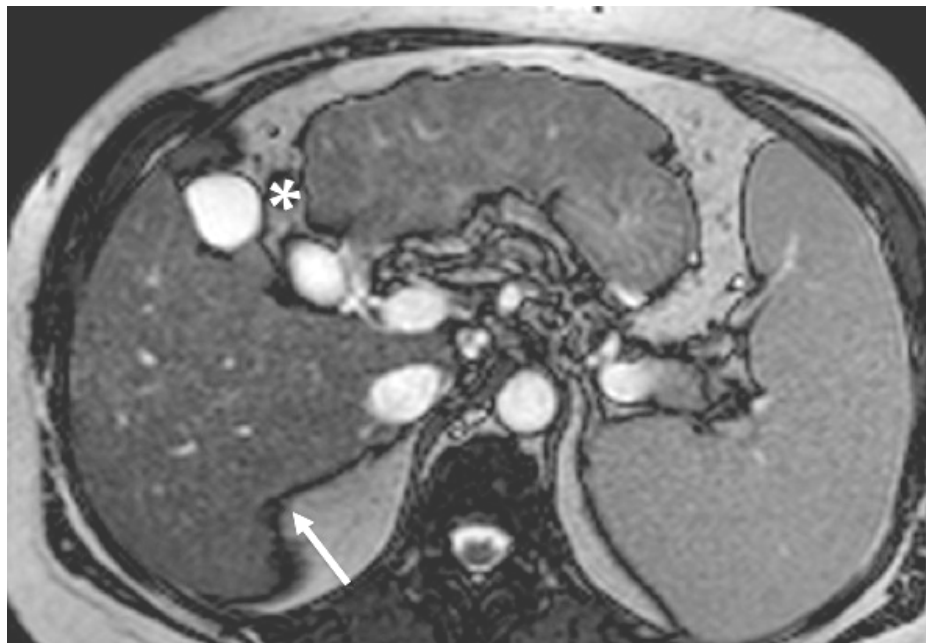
MRI axial image shows a nodular surface liver with splenomegaly and enlarged left liver and edematous gallbladder fossa (asterisk), notching of the right lobe (arrow).
